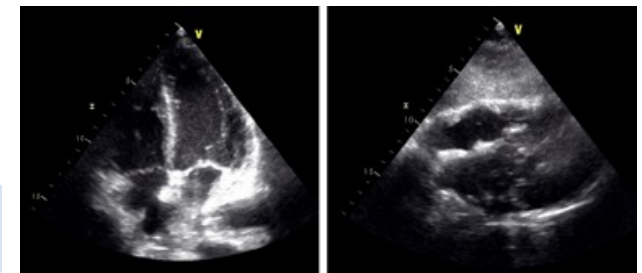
Transthoracic echocardiography (TTE) depicted good biventricular global systolic function and an eodense, heterogeneous mass (30x25mm) at right atrium level, involving tricuspid annulus and basal segment of lateral wall of right ventricle, appearing to extend to pericardium.
